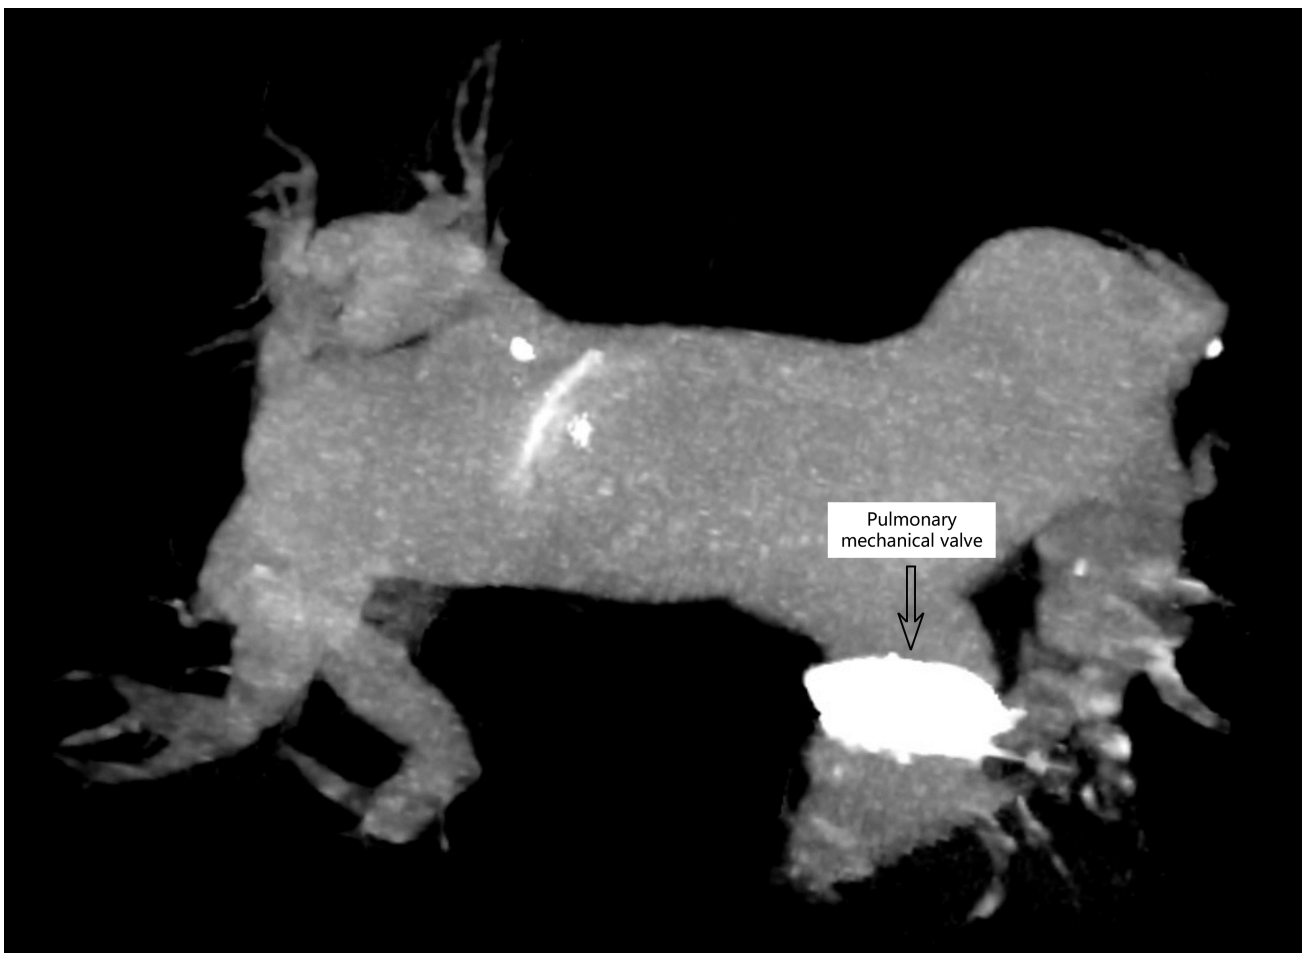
CTA with 3-dimensional reconstruction showed a 52 mm diameter of the main pulmonary artery after surgery, with a well-functioning pulmonary mechanical valve.
